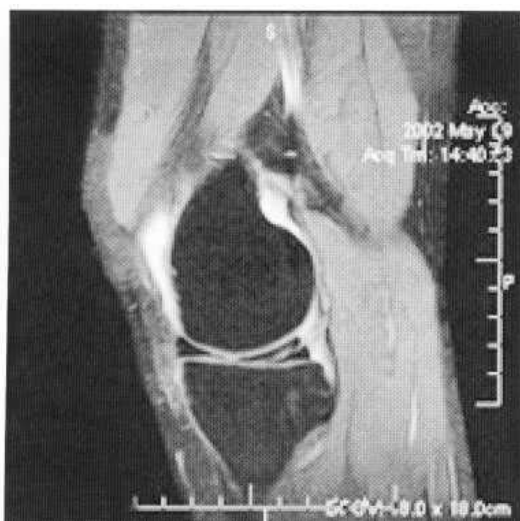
MRI of tear. There is a linear area of increased signal extending through the meniscus to the inferior surface. These changes indicate a complete tear.
